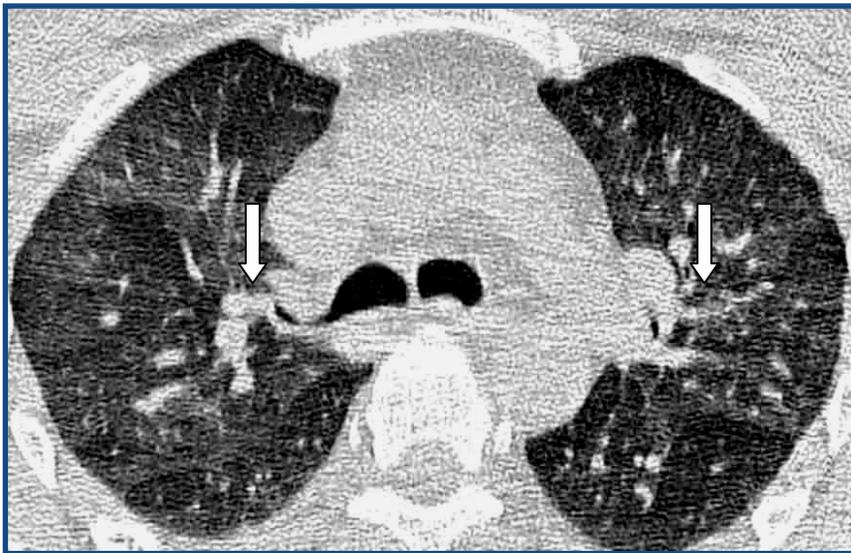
Upper panel shows CT scan taken during inspiration with bronchial thickening (white arrow). Bottom Panel shows CT scan taken during expiration with air-trapping (white arrow).
